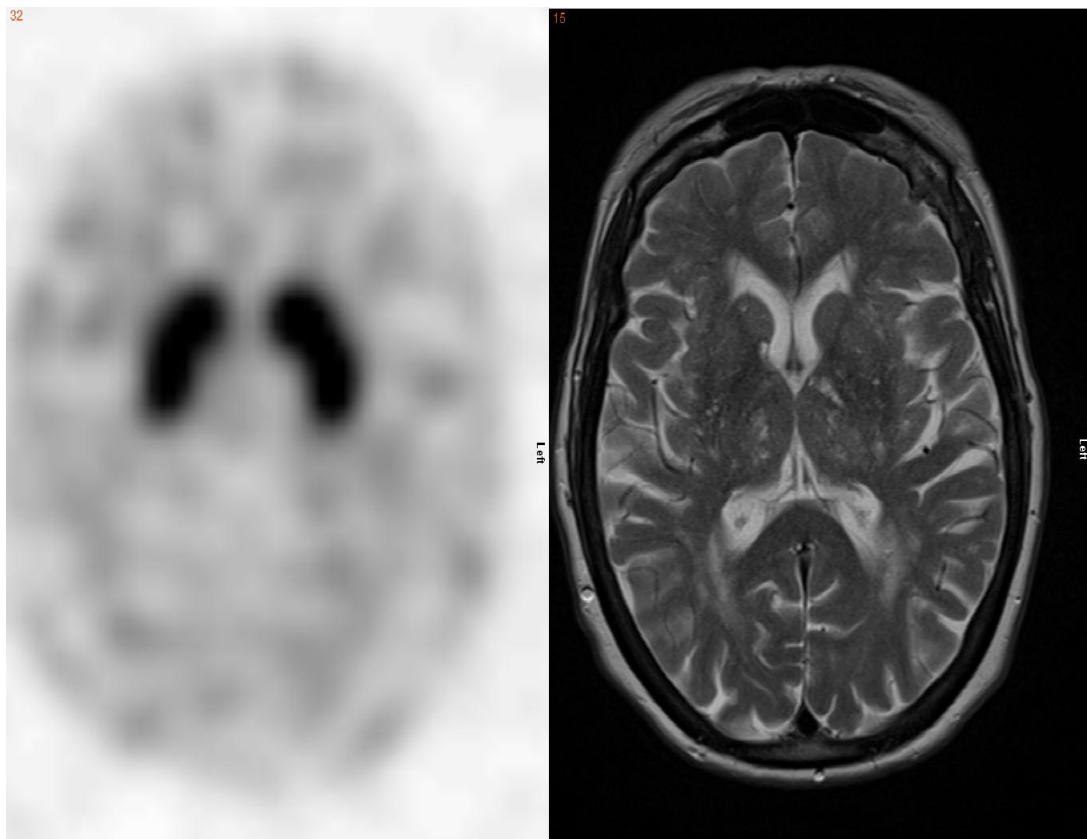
Example transverse slice from ^{123}I -FP-beta-CIT SPECT scan with corresponding slice from T2weighted MRI
